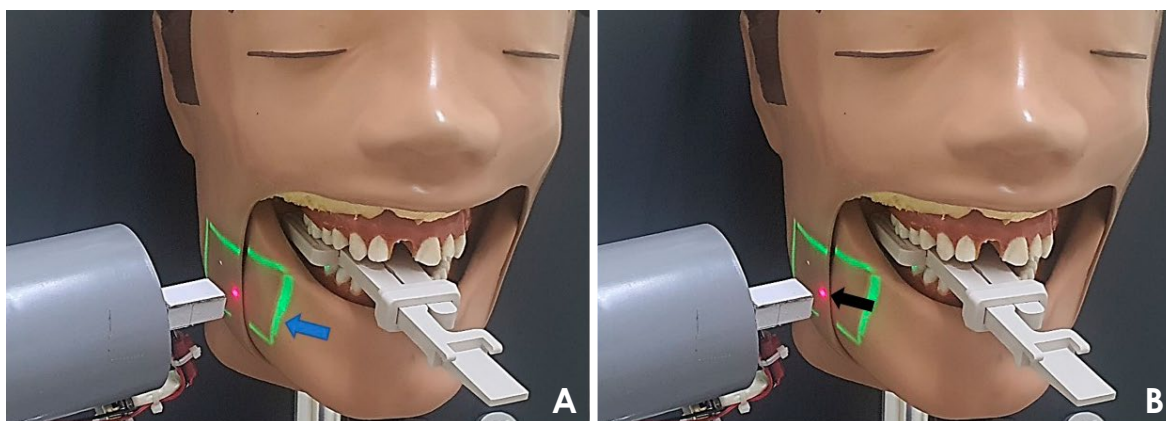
The X-ray cone is fitted with positioning laser lights. A. The blue arrow highlights the green rectangular laser beams, which align with the dimensions of an intraoral film. B. The black arrow indicates the central red laser light positioned at the center of the X-ray cone, marking the entry point of the central X-ray beam.
